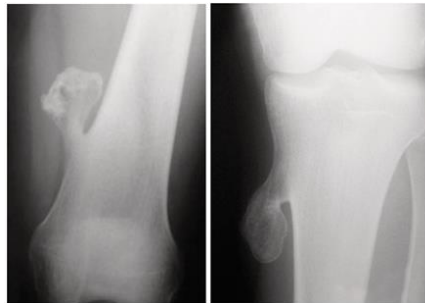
Osteochondroma on Plain Radiograph
